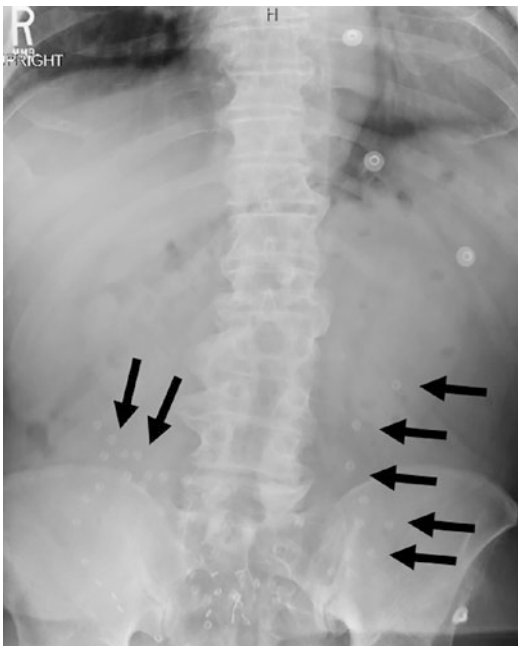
Patient presenting with left lower quadrant focal point tenderness after a suprapubic hernia repair with mesh. Numerous metallic tacks are seen on plain X-Ray (black arrows) on the left and right side
